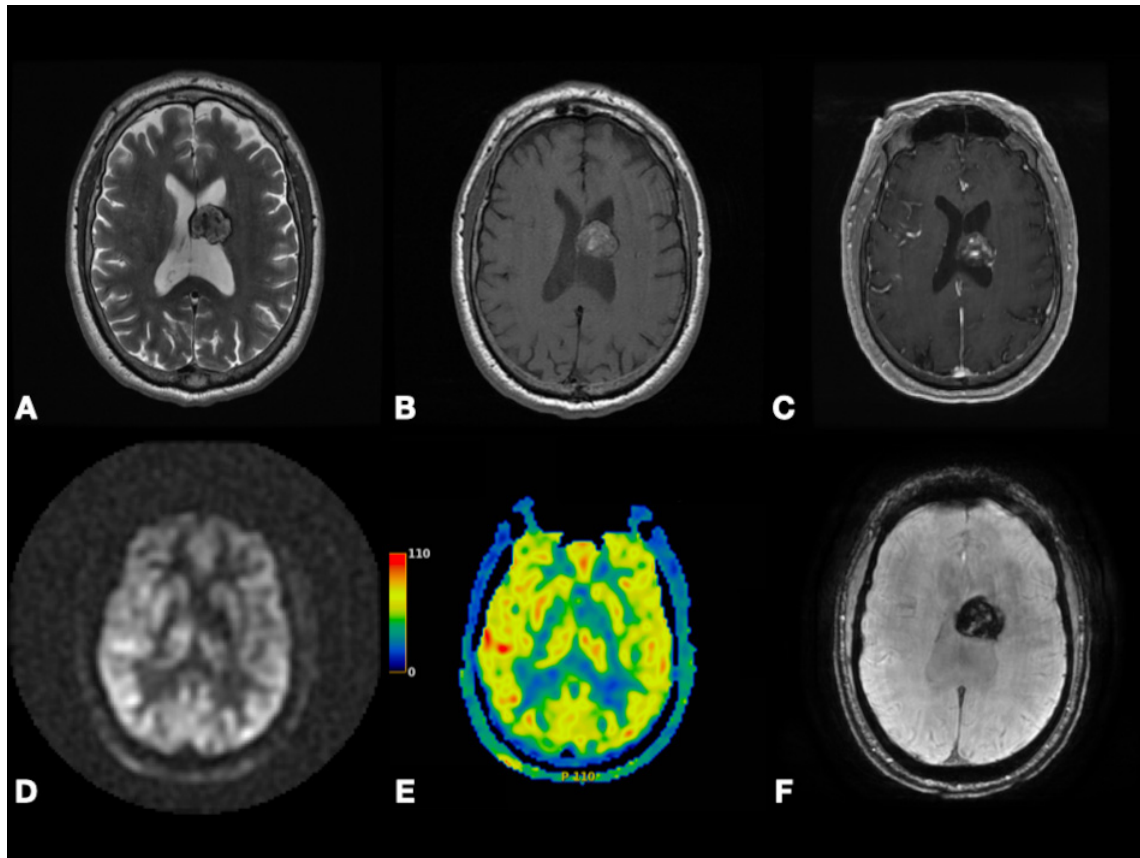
Left lateral ventricle cavernous malformation. Axial T2-weighted (A), pre- and post-contrast T1-weighted (B,C), and SWI (F) images depicting lesion with heterogenous enhancement, heterogenous predominantly hyperintense signal, peripheral hemosiderin rim, and extensive blooming. Axial pcASL source data (D) and color-coded CBF map (E) depicting no hyperperfusion. Abbreviations: SWI, Susceptibility weighted imaging; pcASL, Pseudo-Continuous Arterial Spin Labeling; CBF, cerebral blood flow.
